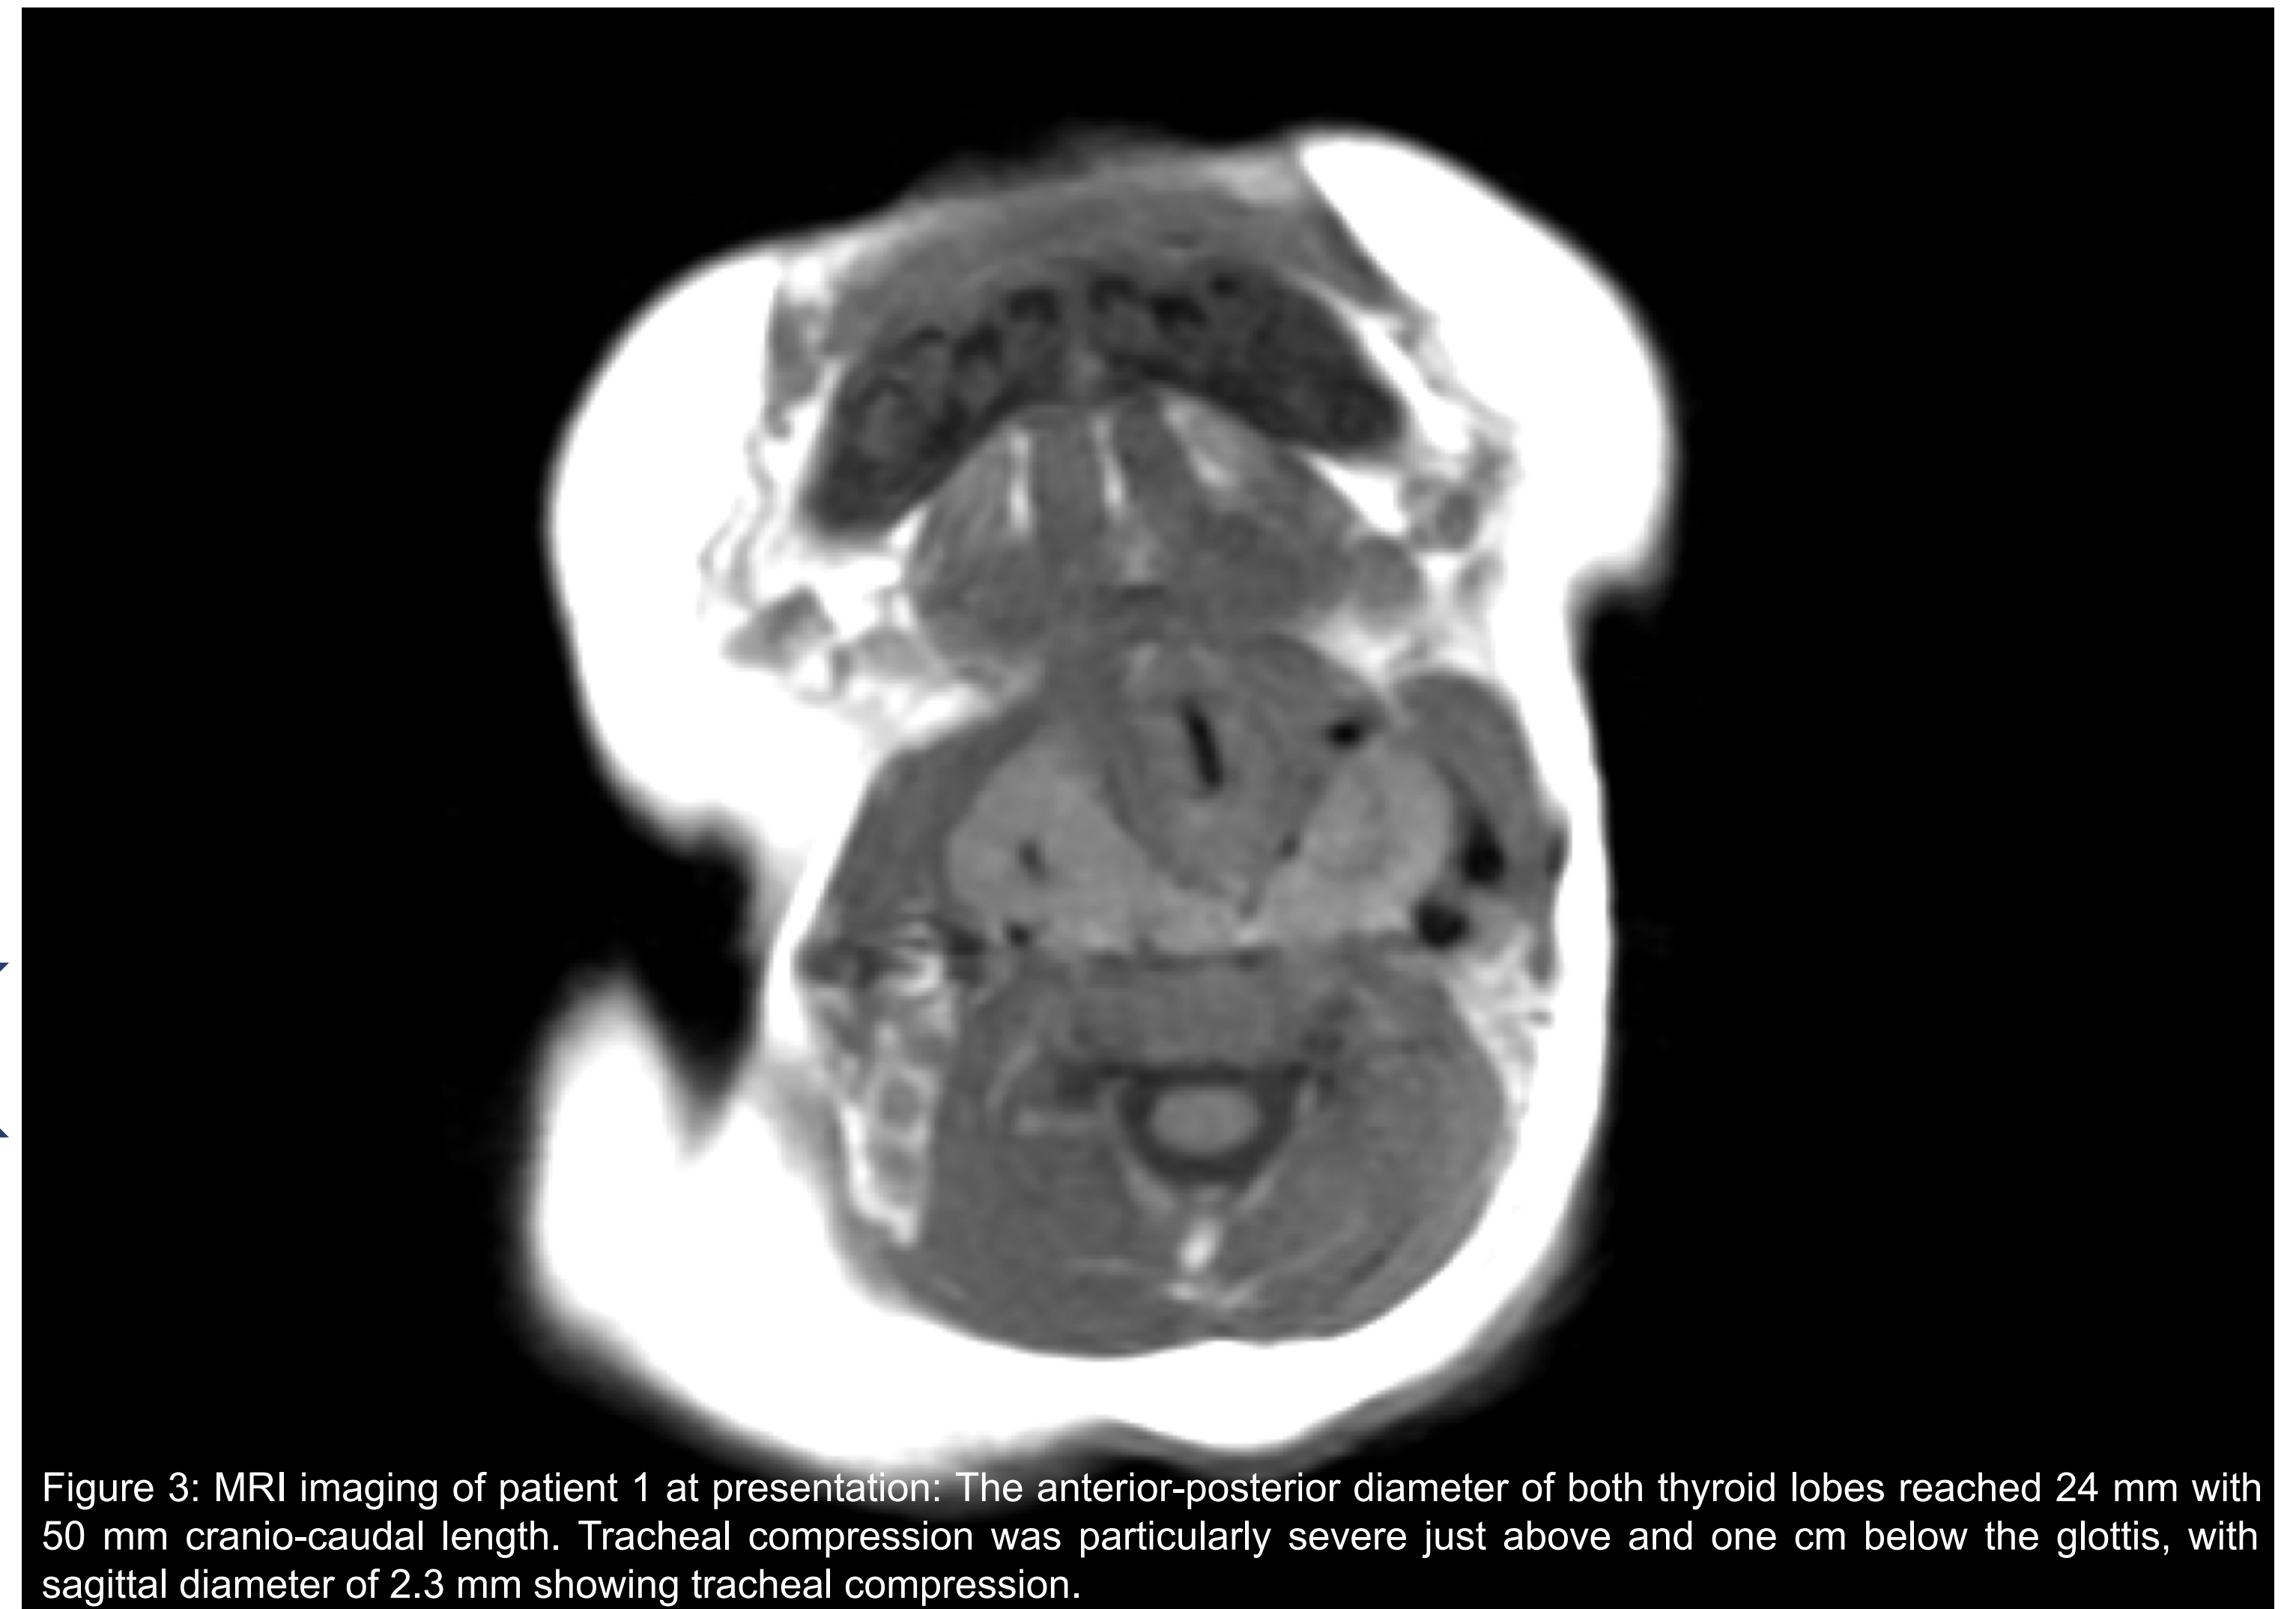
MRI imaging of patient 1 at presentation: The anterior-posterior diameter of both thyroid lobes reached 24 mm with 50 mm cranio-caudal length. Tracheal compression was particularly severe just above and one cm below the glottis, with sagittal diameter of 2.3 mm showing tracheal compression.
